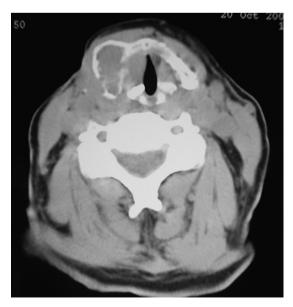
CT scan of larynx without contrast enhancement showing a structural alteration within thyroid cartilage in right ala with cortical thinness.
